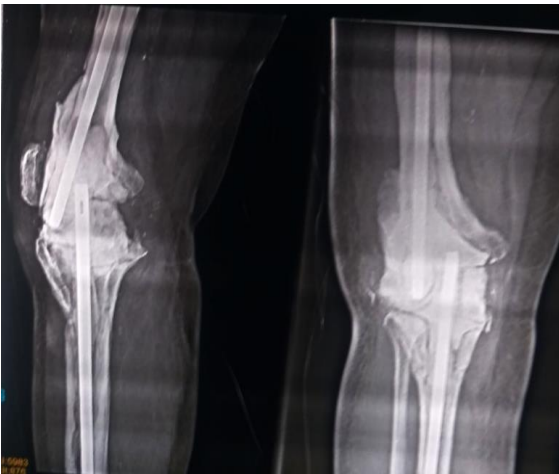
Radiographs showing stage 1 with femoral and tibial K-nail and cement spacer
